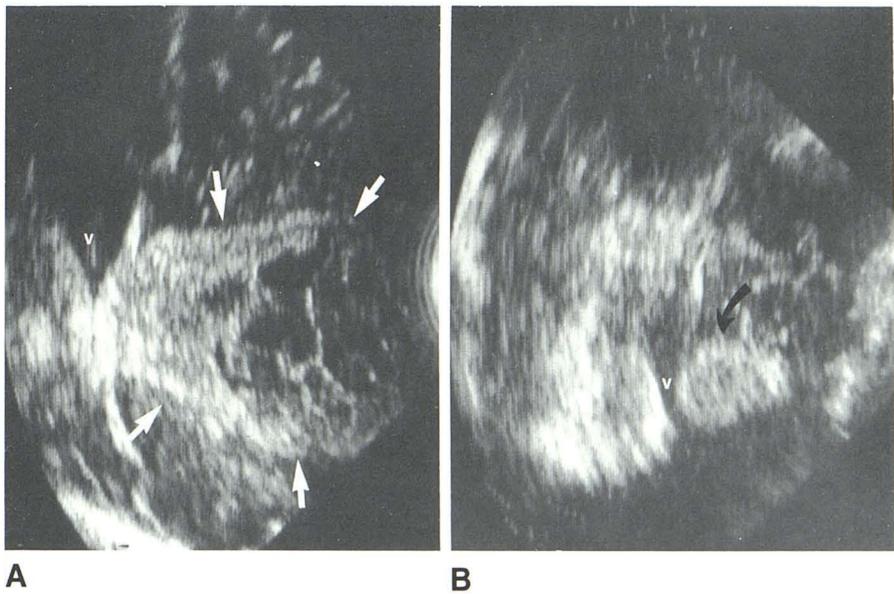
A, Intraoperative sonogram demonstrates glioblastoma multiforme with large multiseptated fluid collection as well as large solid tumor component (arrows). v = ventricle. B, Postoperative sonogram shows residual solid tumor (arrow). Small residual cystic areas are seen to right of arrow.
